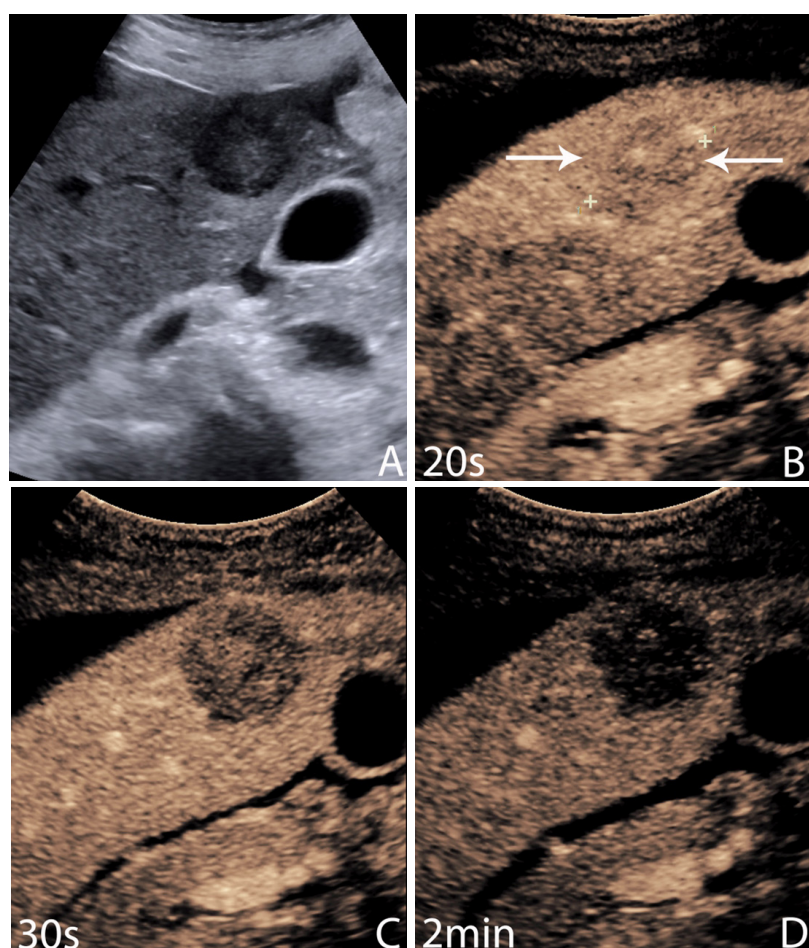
Metastasis. 70-year-old female with abdominal ultrasound performed for right upper quadrant pain, query gallstones. Greyscale ultrasound shows a focal hypoechoic mass in the right lobe of the liver (A); at 20 s, the mass is hypoenhanced, appearing very slightly less bright than the liver (B); at 30 s, there is already washout of the mass, so that it is now much less enhanced than the adjacent liver. It is also less enhanced than it was at 20 s (C); at 2 min, the mass appears as a black hole due to marked washout. This rapid transition from enhancement to washout is typical of metastatic disease. Biopsy showed adenocarcinoma, of unknown origin (D)
